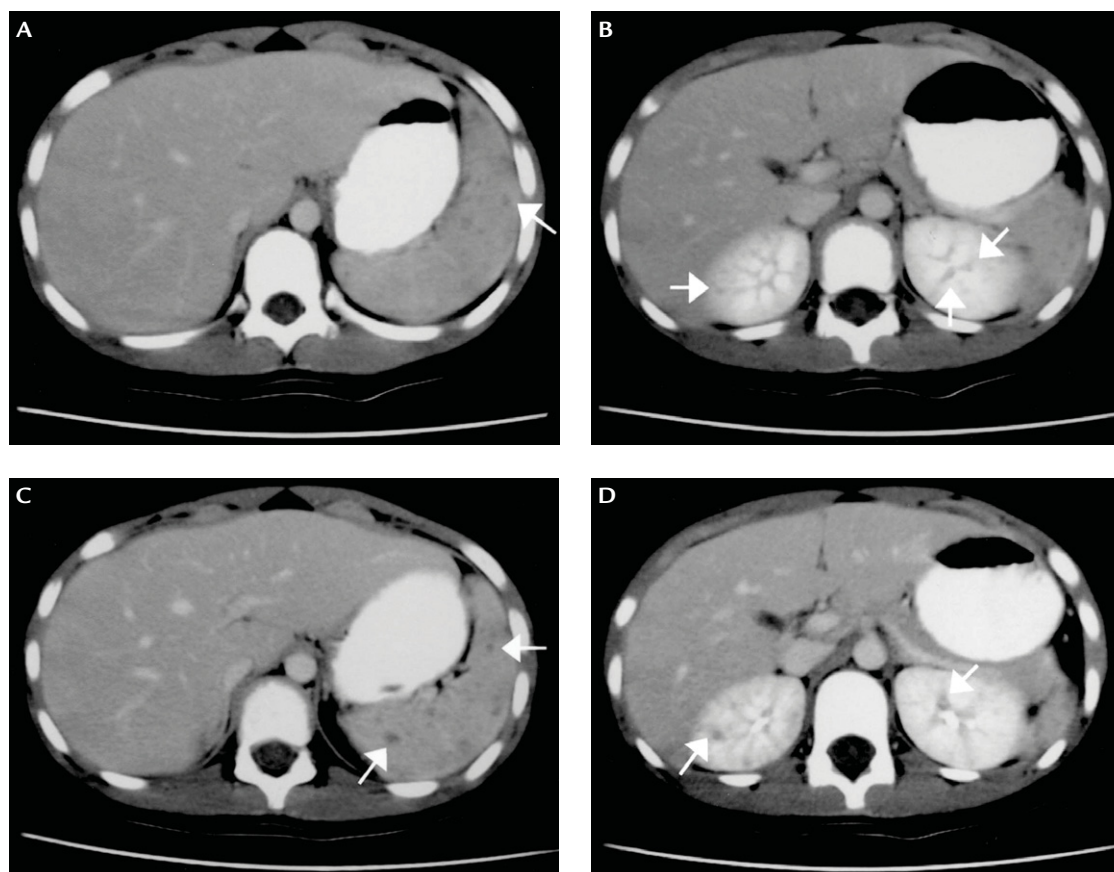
Contrast-enhanced abdominal computed tomography (CT) showing multiple small hypodense nodular lesions (arrows) within the: (A) spleen, and (B) both kidneys. Follow-up CT 8 days later showing the progression of hypodense nodular lesions (arrows) in the (C) spleen, and (D) kidneys.
